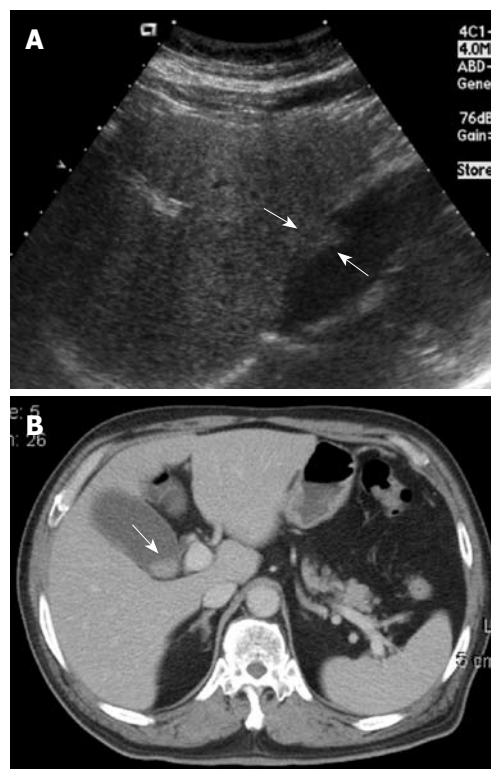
A 68-year-old woman with intermittent dull right upper quadrant pain for 6 mo. A: Ultrasound (US) showed a sessile polypoid lesion (arrows) with a mildly uneven surface; B: Contrast-enhanced computed tomography (CT) showed an intraluminal polypoid lesion (arrow) with no apparent enlarged regional lymph node.
